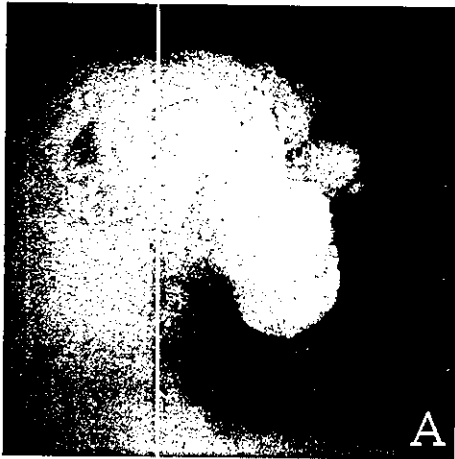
Image diagnosis before initiation of chemoradiation in July 1997: (A) endoscopic picture; (B) computed tomography, direct invasion to the left main bronchus is indicated by arrows; (C) esophagography.
